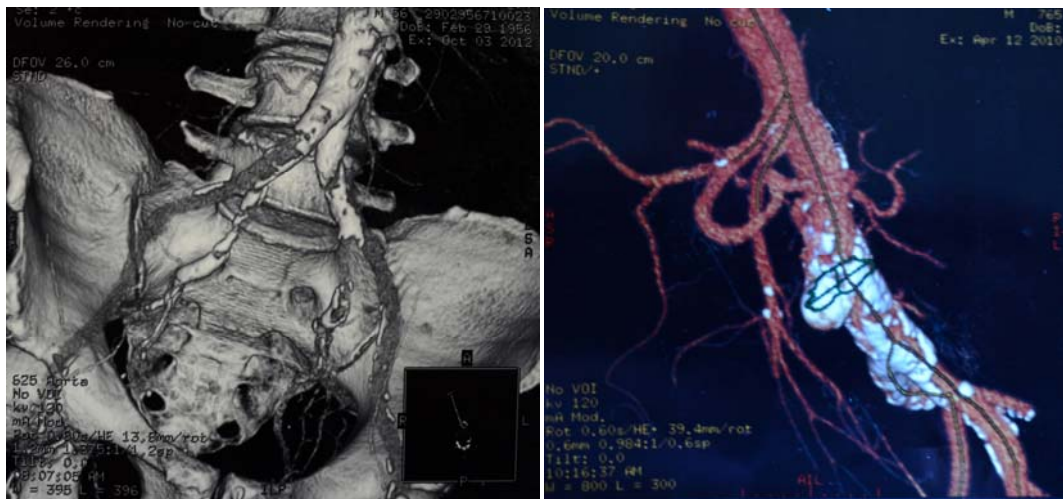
Multislice computed tomography (MSCT) angiography preoperatively.
